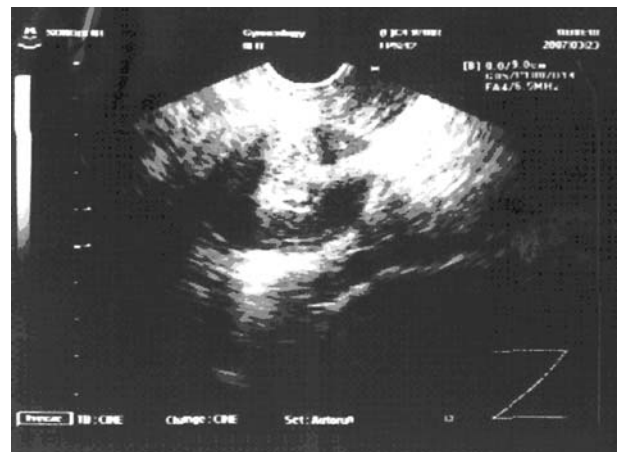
Endovaginal ultrasound image of the tumor on the posterior rectal wall
